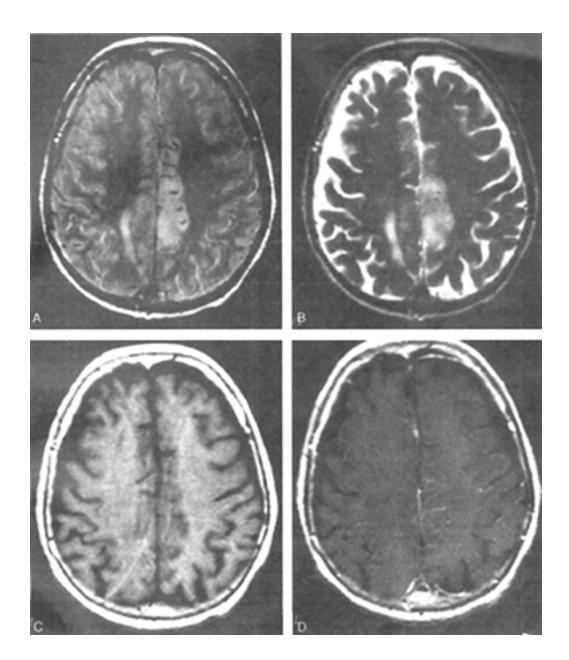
Acute cortical infarction. A and B, Proton-density and T2-weighted axial MRI scans show increased signal intensity within the medial cortex of left frontal and parietal lobes. Note swelling of gray matter and prominence of blood vessels within this lesion. C and D T1-weighted axial MRI scans before and after gadolinium administration demonstrate several linear foci of contrast enhancement within the area of infarction in the left frontal and parietal lobes, most consistent with enhancing arterial branches. Contrast enhancement of arterial branches is consistent with static blood flow within the infarct, and generally is seen only within the first few hours to 5 days after the onset of acute infarction. (Reprinted with permission from Rowland LP, editor: *Merritt's Textbook of Neurology*, ed 9. Williams & Wilkins, Baltimore, 1995.)
